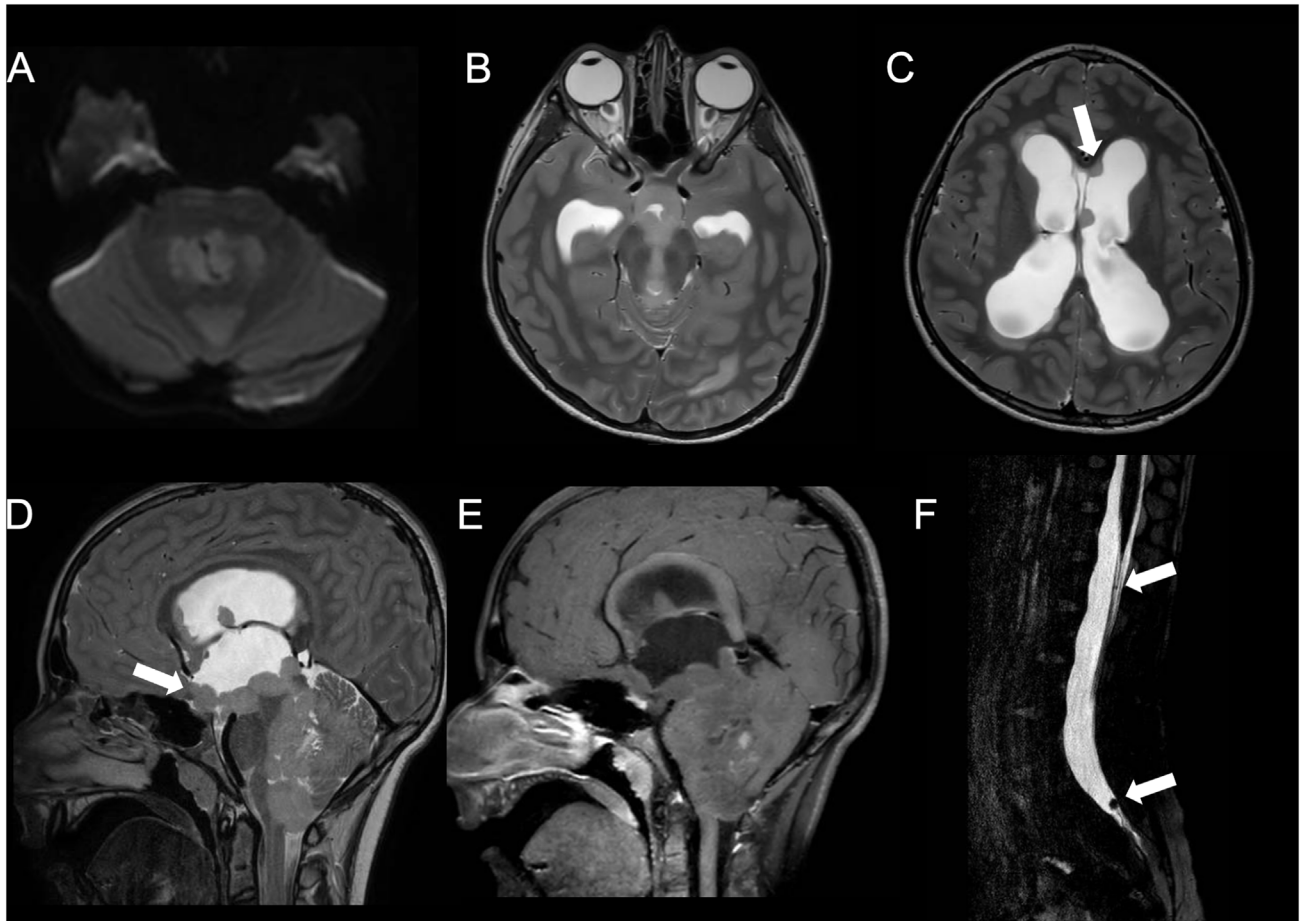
Magnetic resonance (MR) images of an 11-year-old boy with medulloblastoma. Axial (A) diffusion-weighted imaging (DWI) and (B,C) T2-weighted images, (D) sagittal T2-weighted and (E) T1-postcontrast images, and (F) spinal sagittal T2-DRIVE images show a bulky mass lesion in the fourth ventricle and mesencephalic aqueduct with nodular dissemination in lateral ventricles and in the spinal cord (*arrows*). Lesions determined supratentorial hydrocephalus.
